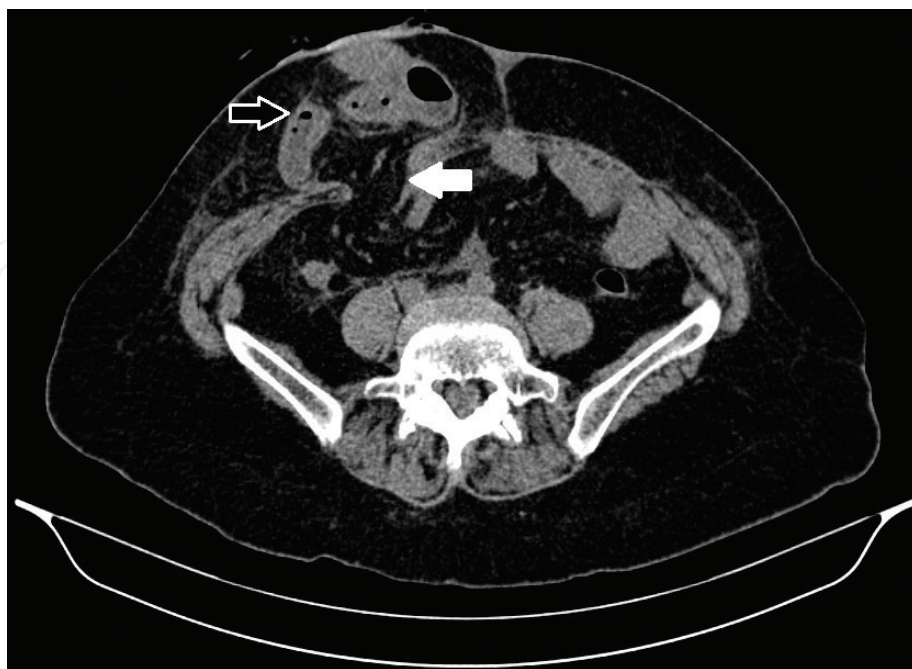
An axial CT scan showing a fascial defect (white arrow) and a parastomal hernia (black/white arrow).
